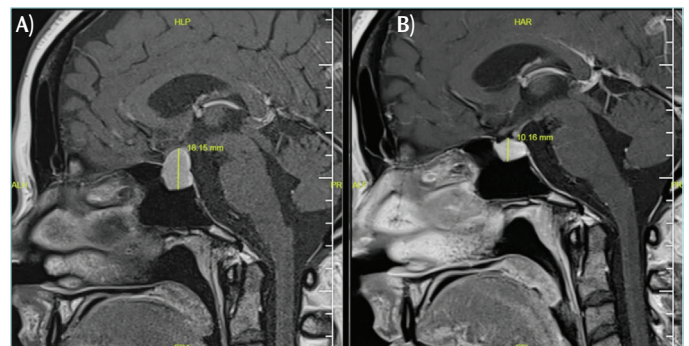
Contrast-enhanced magnetic resonance imaging; (A) T1A sagittal section at admission. (B) T1A sagittal section 7 months after initiating levothyroxine treatment.
